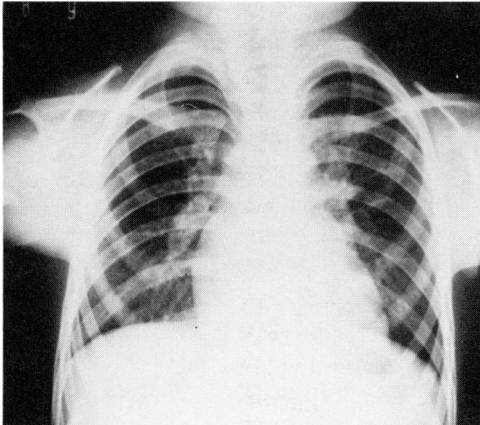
First chest X-ray film (Case 5).
